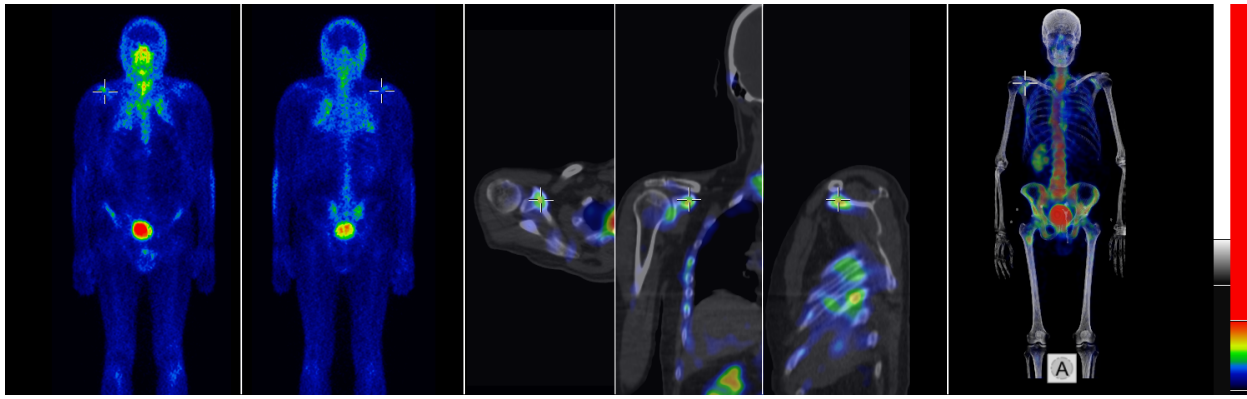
Example layout for evaluating our whole body SPECT studies. First two images show the artificial anterior - posterior image pairs. Middle three images show the axial-sagittal-coronal views of the fused whole body SPECT-CT. Last image shows the volume rendering view of the fused whole body SPECT-CT. Note the synchronized cursor position representing a hotspot in the shoulder.
